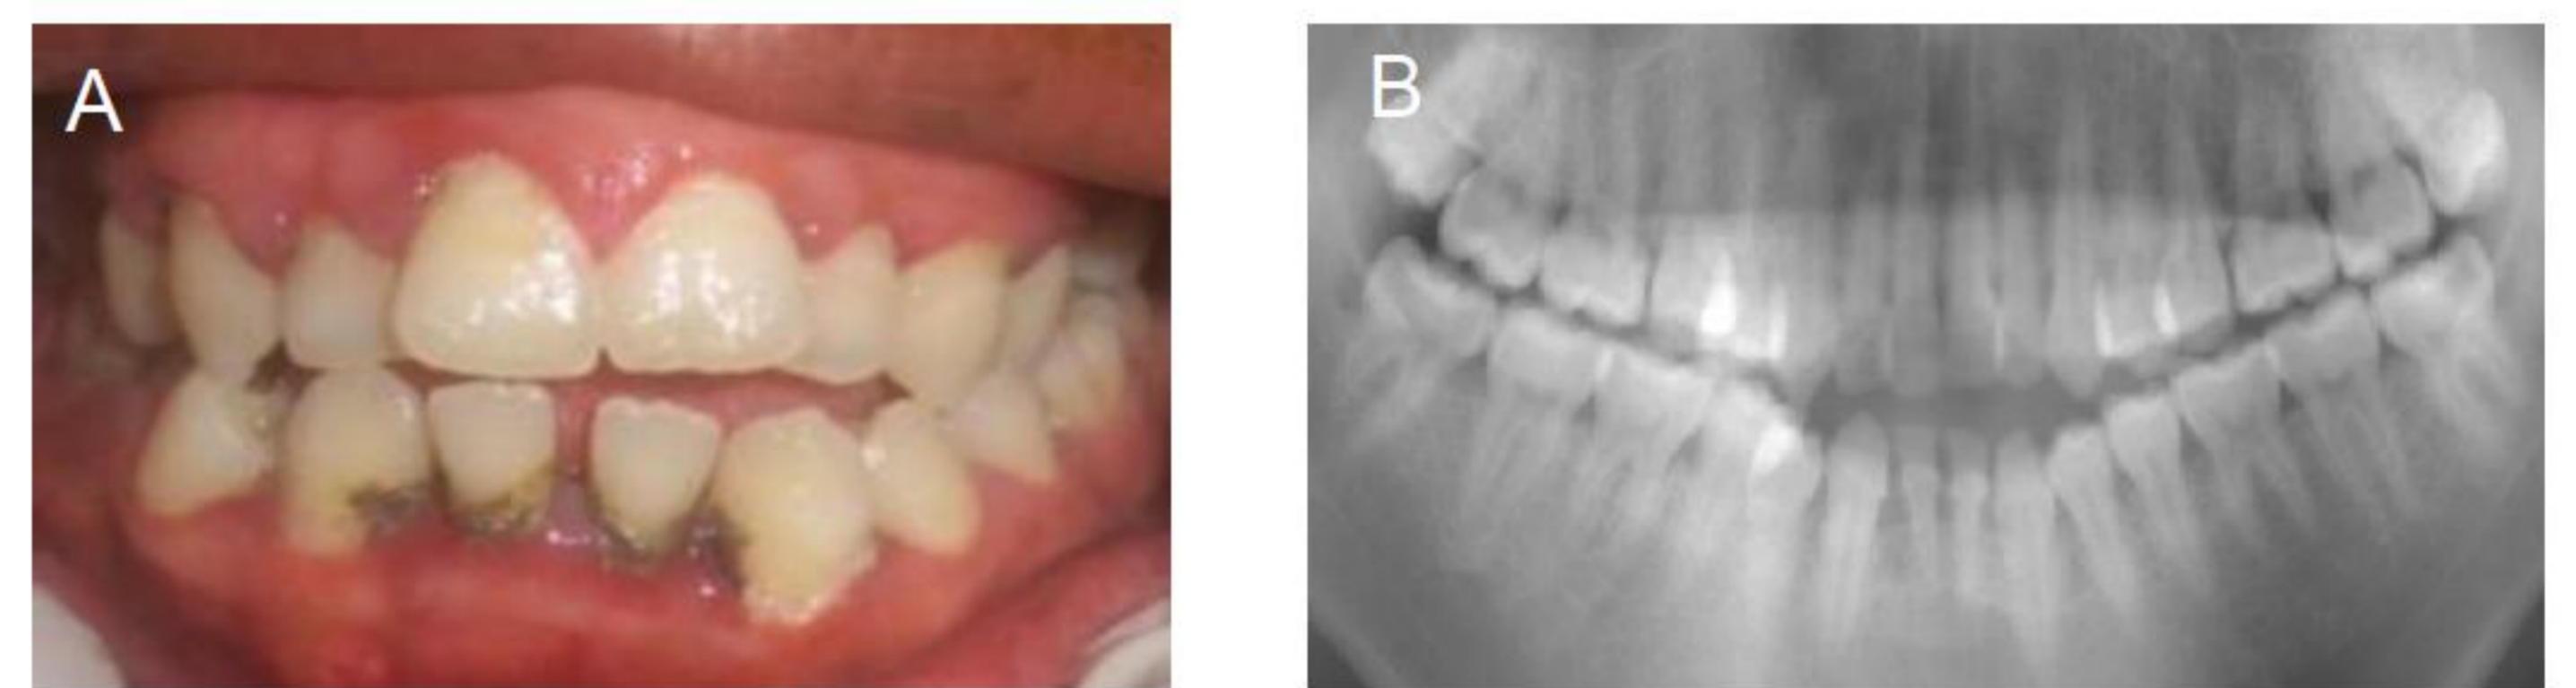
Hemophilia B patient aged 35 with generalized chronic periodontitis (A). Panoramic radiography showing generalized alveolar bone loss (B).
